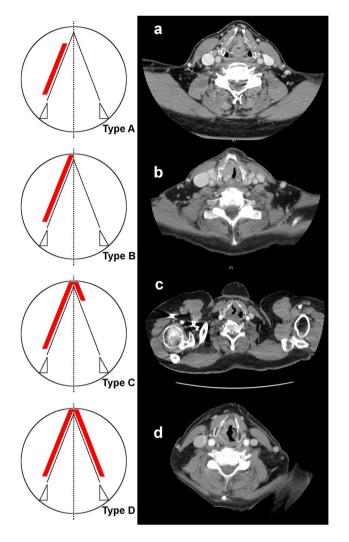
Proposed classification scheme for midline relation of laryngeal cancer with corresponding CT scans. Type A: clear (a), type B: involved (b), type C: exceeded (c), type D: bilateral growth/origin side indeterminable (d)
